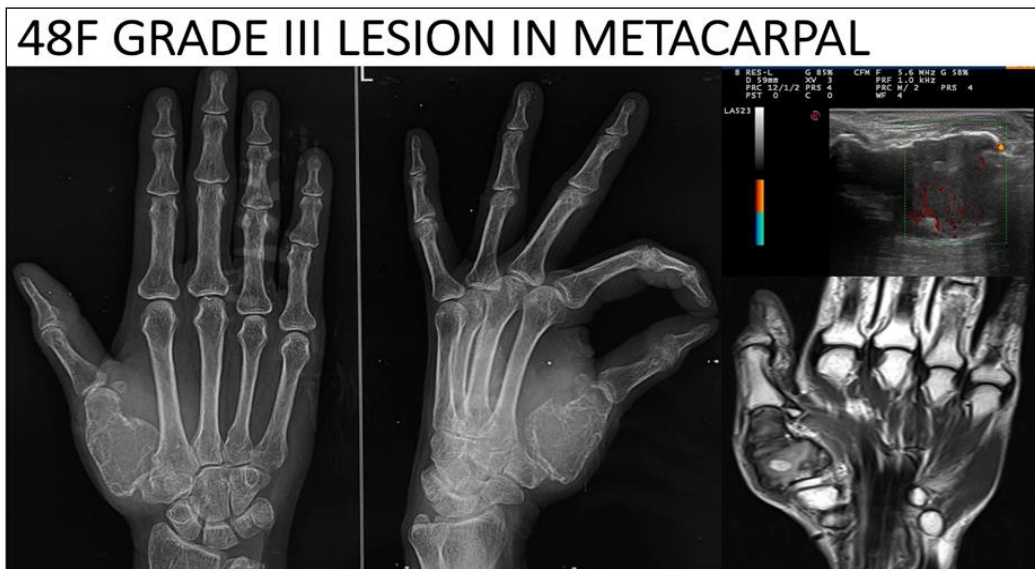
Grade III lesion in 1st metacarpal. Gross expansion of bone and soap bubble appearance and cortical discontinuity are well depicted on radiograph
